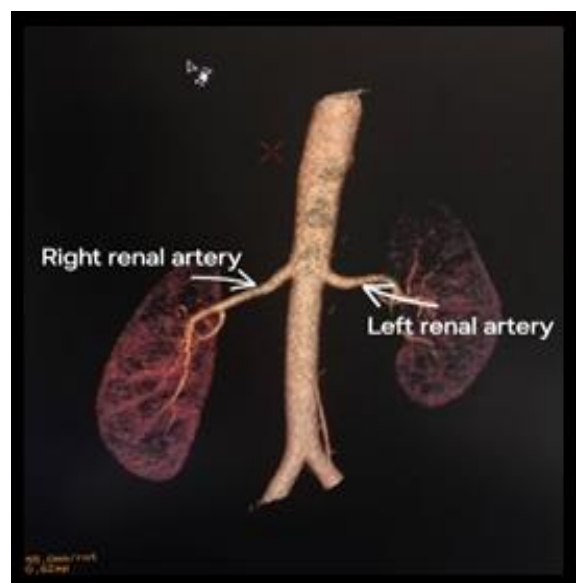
Computed tomography arterial phase images showing classical configuration of Renal artery, bilateral single renal artery
